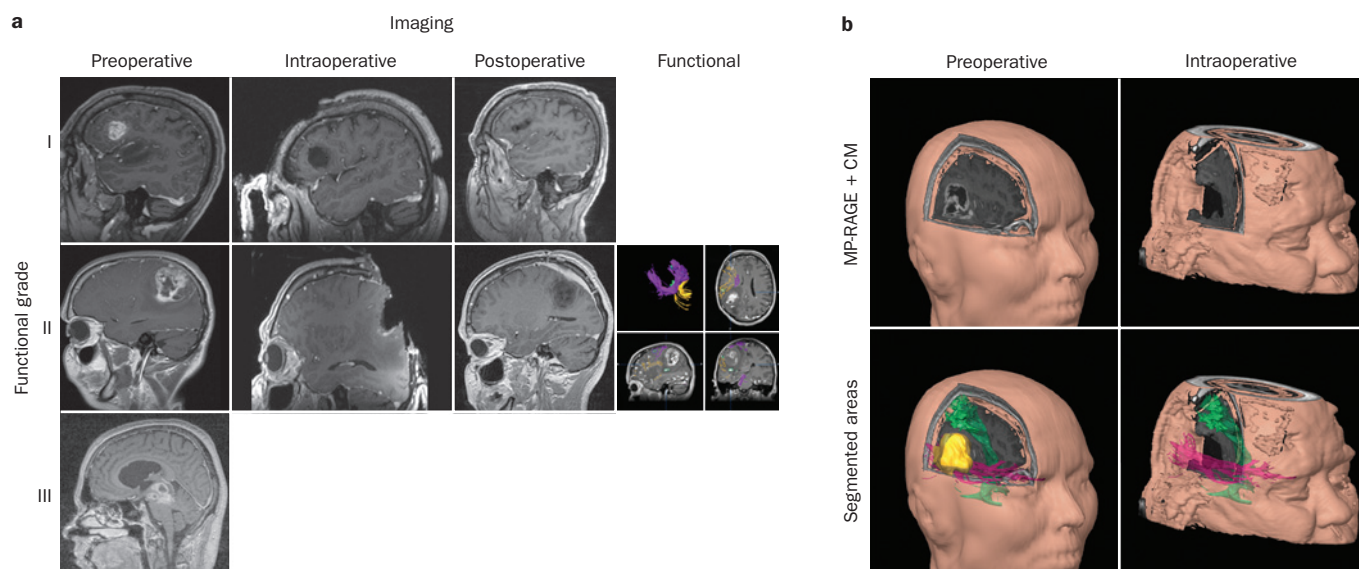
Functional grading and imaging of malignant gliomas and surgical planning. a | Preoperative T1-weighted contrast-enhanced MRI depicting tumour location in relation to expected anatomical location of functionally eloquent brain areas. Functional grade I tumour: iMRI depicts gross total resection without the need for functional imaging studies. Functional grade II tumour: preoperative functional imaging defines tumour location with respect to functionally eloquent brain areas, thereby permitting gross total resection as documented in the iMRI scans. Functional grade III tumours: localization within eloquent areas, as shown in preoperative imaging in the case of a malignant brainstem glioma, makes radical surgery impossible. b | State-of-the-art functional neuronavigation depicting functionally eloquent brain areas and their relationship to the brain tumour for thorough surgical planning. Left panels: 3D depiction of the tumour using MP-RAGE+CM (top image) and the volumetrically segmented tumour (yellow regions) as well as visualization of the pyramidal (green regions) and visual (pink regions) fibre tracts (bottom image). Right panels: 3D depiction of the intraoperative resection control (top) and the postresectional visualization of the intact pyramidal and visual tracts (bottom). Such operative planning aids in determining the feasibility of gross total and/or possible extent of tumour resection. Abbreviations: iMRI, intraoperative MRI; MP-RAGE+CM, magnetization prepared rapid gradient-echo with contrast medium.
